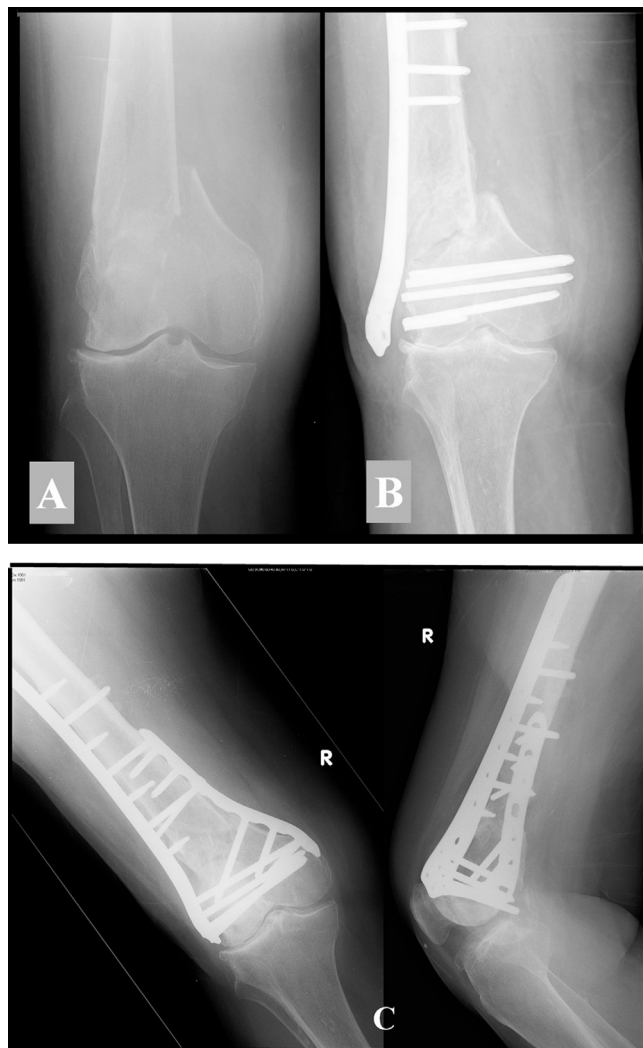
A 92-year-old female with a Type 33-A3 supracondylar femur fracture (a) initially treated by a lateral locking plate. Hardware breakage and nonunion were detected 5 months following surgery (b). A double-plating procedure was performed, and good radiographic healing of the fracture was observed 2 years following the injury (c).
